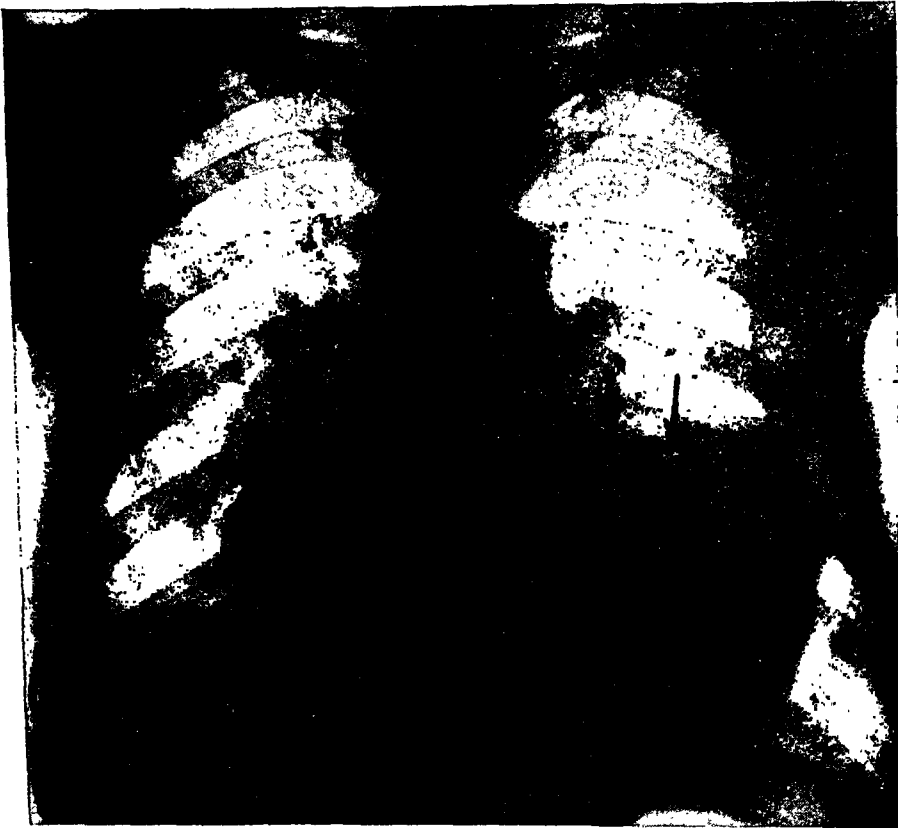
Same heart 10 years after the onset of cardiac infarction. Calcified plaques were noted in the left lower cardiac contour; a double row of calcification was seen in the original roentgenogram (site indicated by arrows) within the coronary arteries.
